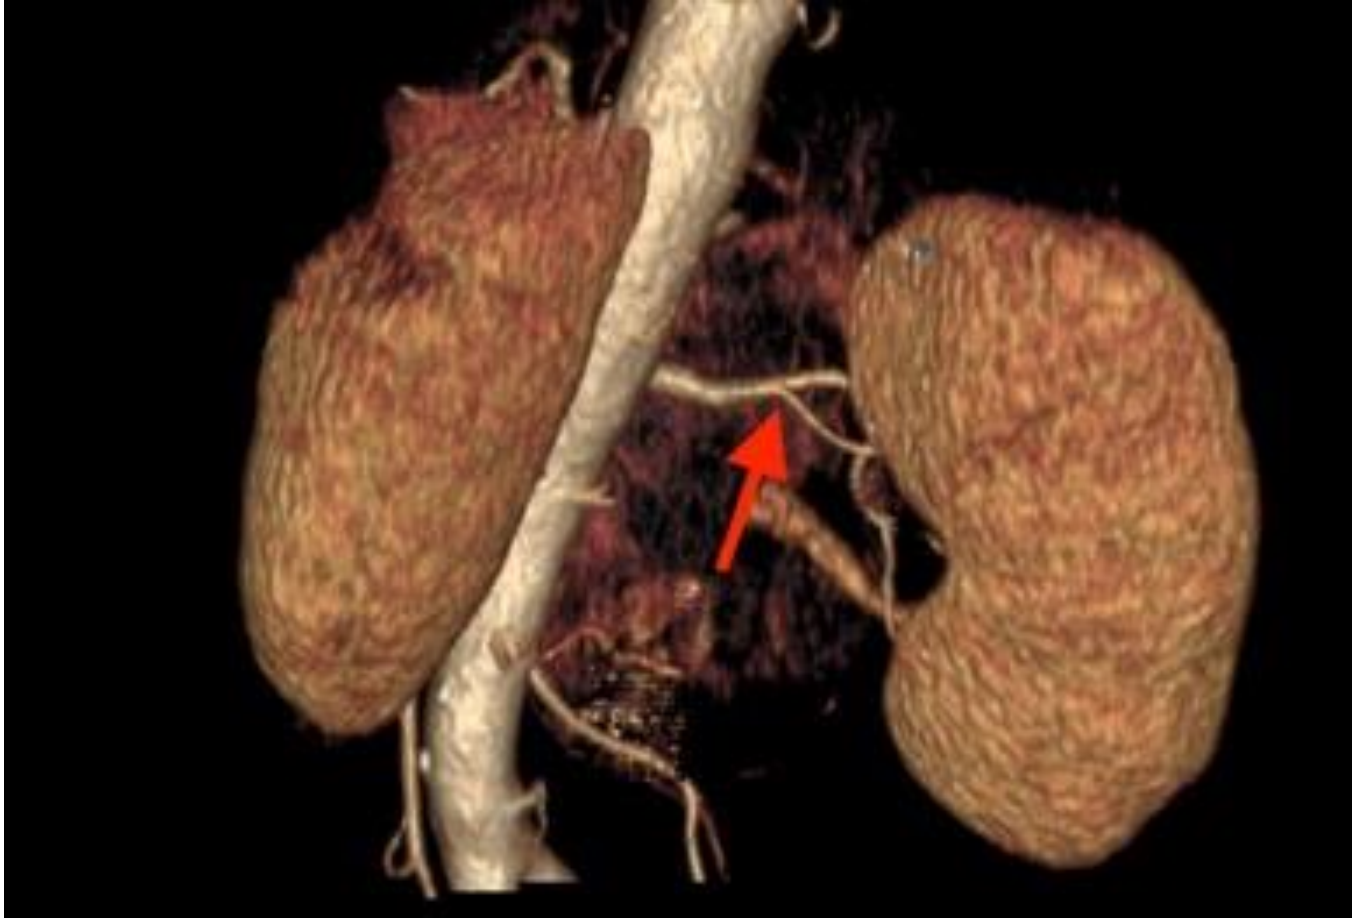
Prehilar branching of left kidney artery in computed tomography angiography image (Red arrow)
